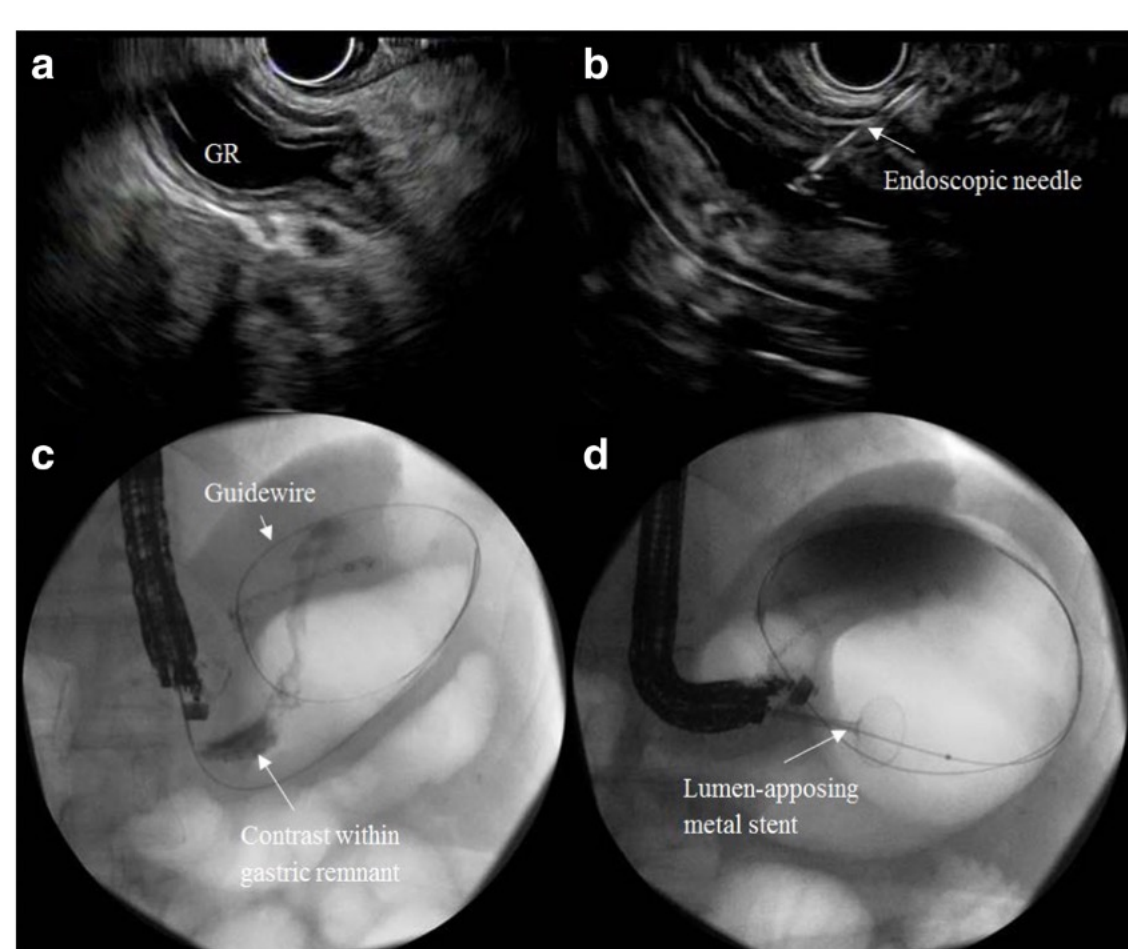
Gastrogastrostomy. Sonographic characteristics of gastric remnant (GR) (a). Gastric remnant punctured with a 19-gauge Flex endoscopic needle (b). Contrast injected into the remnant stomach and position confirmed on fluoroscopy (c). LAMS deployed under fluoroscopic guidance (d).²
